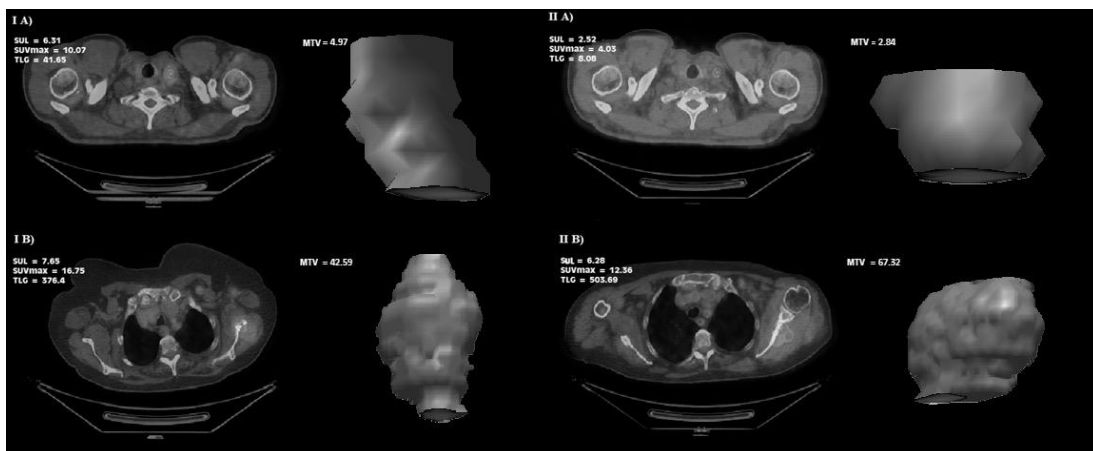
The highest 18F-FDG uptake lesion before treatment (I) and after treatment (II) with relative MTV in two patients with multiple metastases. Patient A is classified as a responder in all metabolic classifications showing 60% decrease in SUV and SUL, 80% decrease in TLG, and 42% decrease in MTV. Patient B is classified as a responder in $\text{EORTC}_{25\%}$ and $\text{EORTC}_{15\%}$ (-26%), and as a non-responder according to PERCIST (-18%), Δ TLG (+33%), and Δ MTV (+58%).
